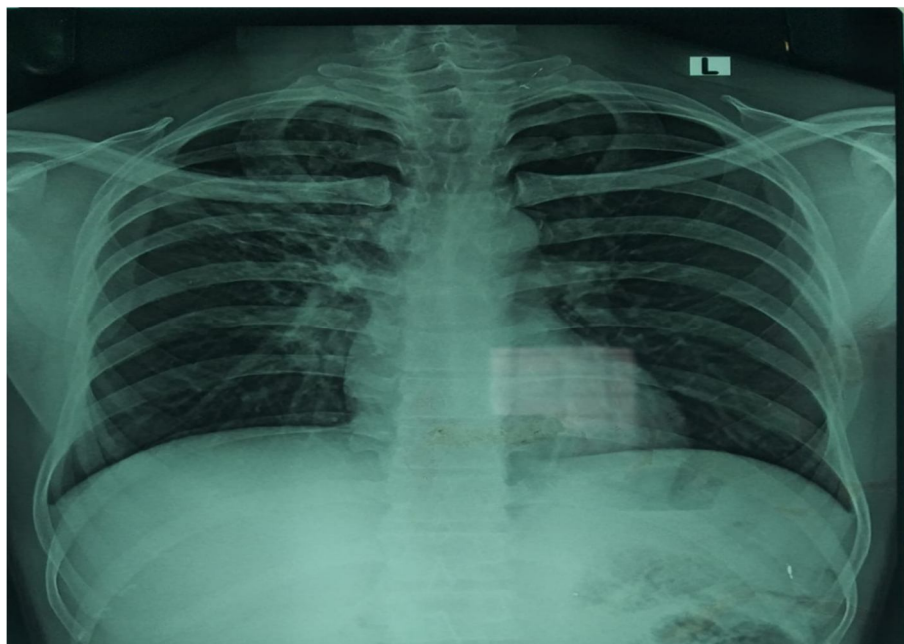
Chest X-ray of patient (Bilateral prominent markings with hyper inflated lungs)
